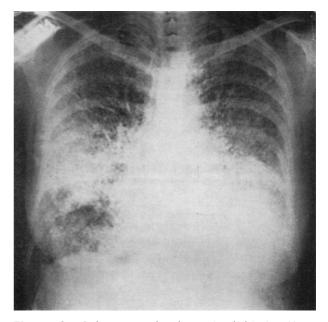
Pulmonary alveolar microlithiasis: X-ray pattern of lungs. By Lauta V.M.: "La funzione undulopodica dell'epitelio bronchiale nella microlitiasi endoalveolare del polmone studiata con curve di eliminazione di particelle di Au¹⁹⁸ e con scintigrafie polmonari". Atti Ac Pugl Sci 1980; 18: 13–44.
